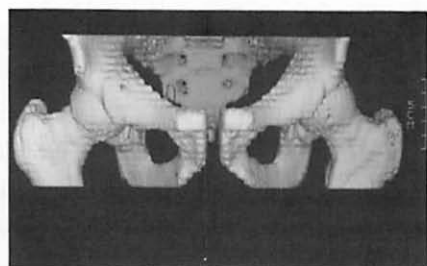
3D-Rendering of a Spiral-CT 5mm/5mm reconstructed each 2mm
